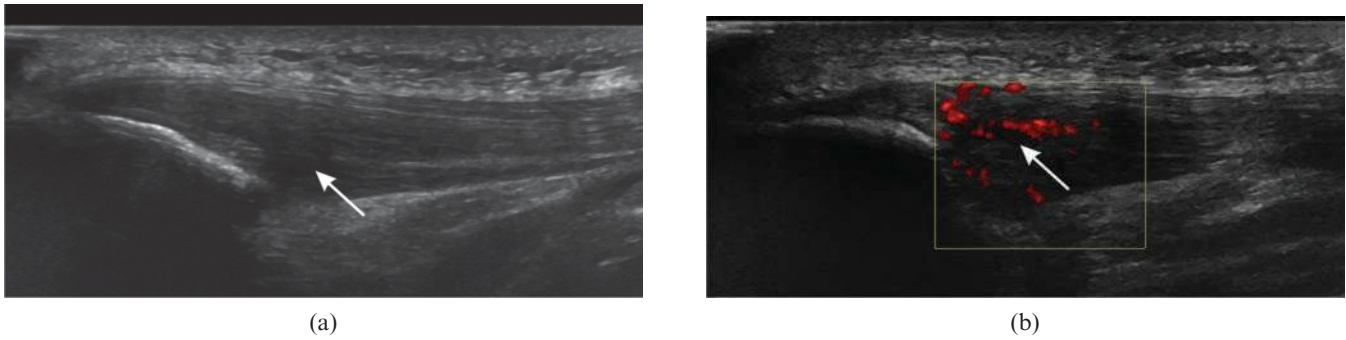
Patellar tendinosis. (a) Longitudinal ultrasound of the patellar tendon near the inferior pole of the patella shows hypoechoic thickening (arrow). (b) Power Doppler shows neovascularisation of the tendinopathic region (arrow).
